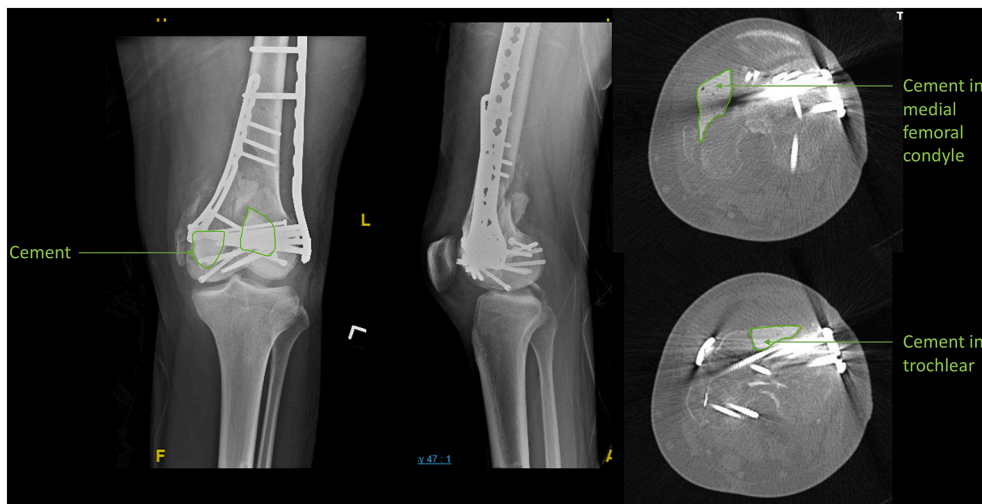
Post-fixation radiographs with cement spacer inserted over area of articular bone loss.
